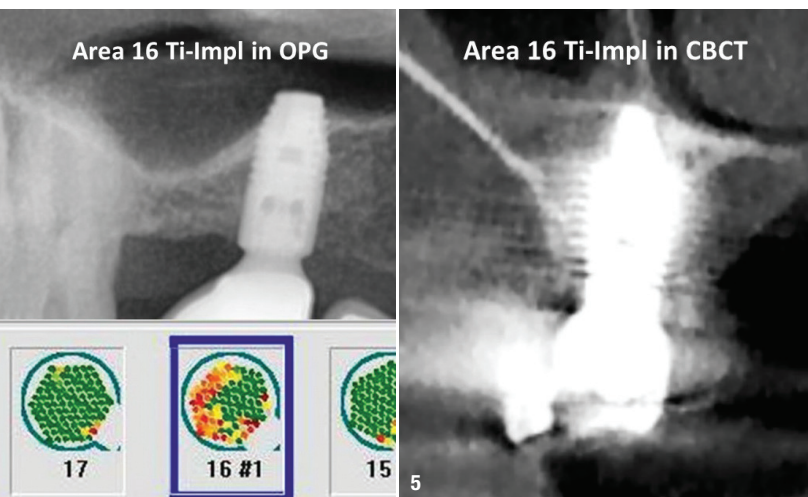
Implant area 16 with no detectable FDOJ/BMDJ or osteoimmune dysfunction on BIC in OPG (left) and CBCT (right). Below OPG the sonographic displaying bone density in red (soft and inflammatory) and in green (healthy jawbone).
